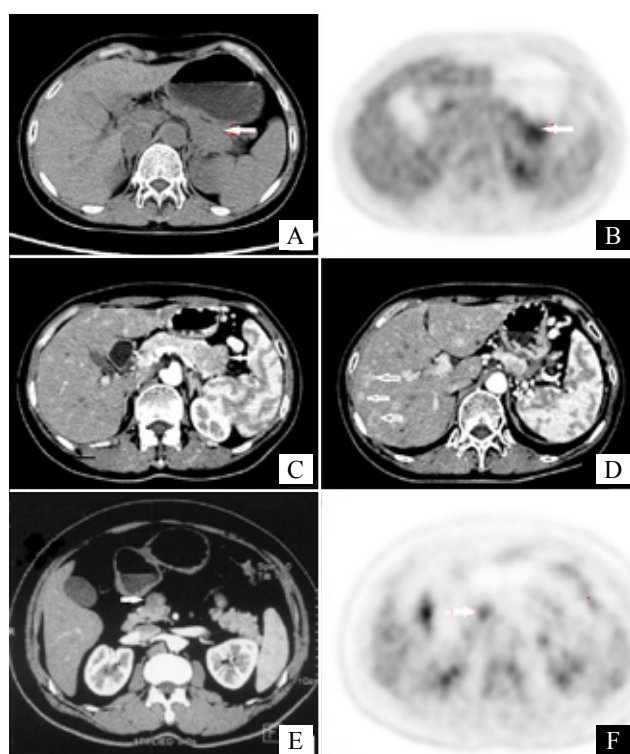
A pathology proven malignant SPT with hepatic metastasis located in the pancreatic tail of a 55 years old woman showed mild ^{18}F -FDG uptake with SUVmax value as 3.7 (B, solid white arrow), and exhibited hypoattenuation at the arterial phase after contrast administration (C, solid white arrow). The PET image failed to display the lesions in the liver which were identified as hyperenhanced small nodules or circles at the arterial phase after contrast administration (D, empty white arrows). Another pathology proven malignant SPT with capsule invasion located in the pancreatic neck of a 42 years old man exhibited hypovascular enhancement at the arterial phase after contrast administration (E, solid white arrow), and also showed mild ^{18}F -FDG uptake with SUVmax value as 4.0 (F, solid white arrow).
